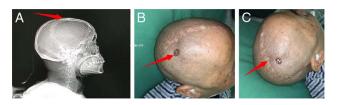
Preoperative assessment. A, skull CT showed that the titanium mesh was exposed in patient frontal region. B, the titanium mesh was exposed in patient frontal region, about 1.5 cm × 1.8 cm in size. C, There was hyperplasis of the scar in the old surgical incision area with thin local skull and shrunken local scalp.
